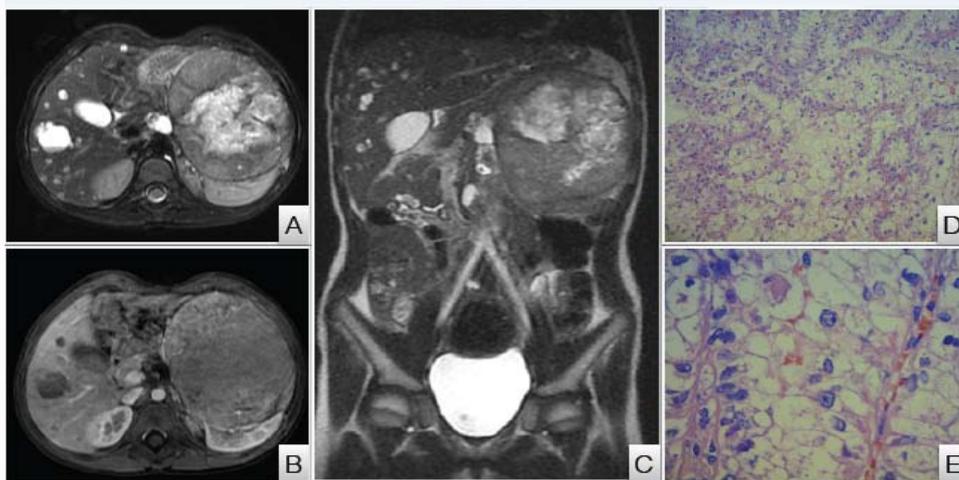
MRI (diagnosis - October 2011). A) T2, B) T1 with contrast, C) T2 coronal, D, E) Pathology confirmation.
